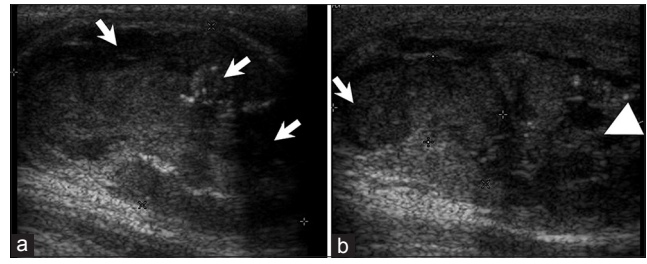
31-year-old man with tubercular orchitis. (a, b) Longitudinal ultrasound images of the testis demonstrate enlarged, markedly heterogeneous hypoechoic appearance of the testis (arrows) with an ill-defined collection (arrowhead, b) in the lower pole.
